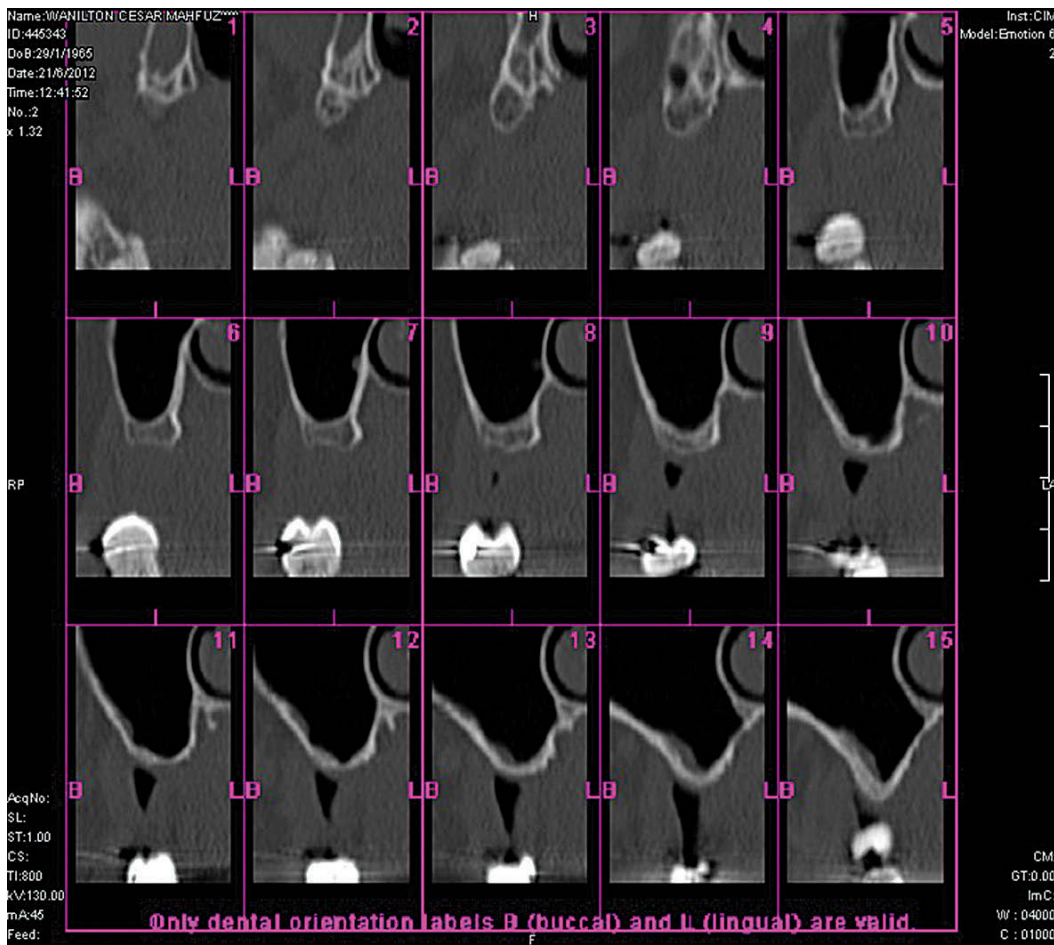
Sagittal CT scan reveals absence of bone tissue (maxillary sinus pneumatization) in right posterior maxilla.
